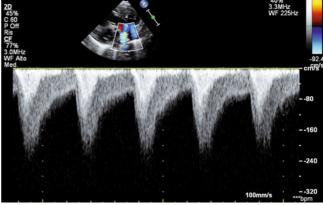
Doppler sample: A continuous wave Doppler pattern at the level of the coarctation showing significant diastolic tail
